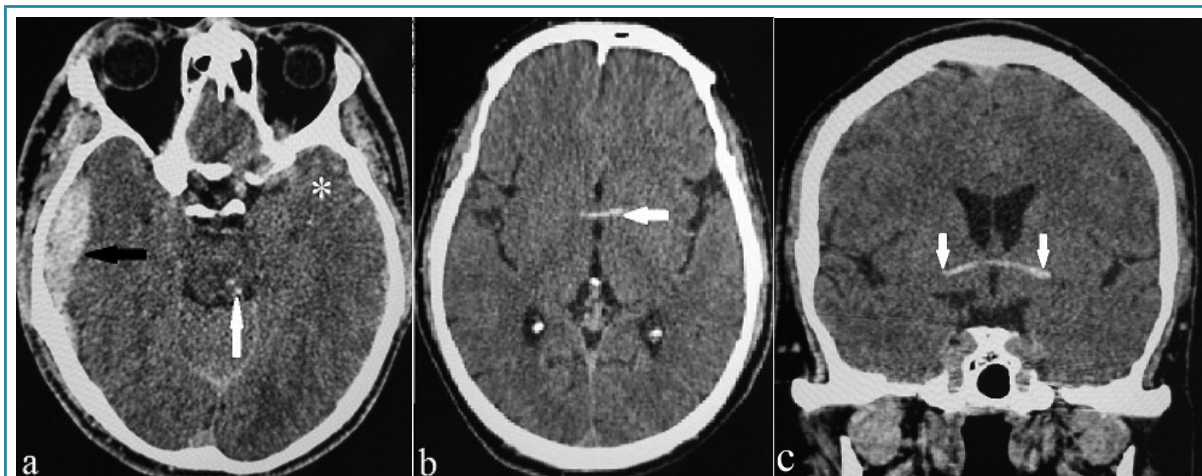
Diffuse axonal injury. (a) Non-contrast axial CT image of a 22 years old male after RTA demonstrates two petechial hemorrhages (white arrow) in posterolateral aspect of mid-brain with right temporal region EDH (black arrow), left temporal lobe contusion (*) and right temporal bone fracture (not shown). (b, c) Axial and coronal reformatted images of 33-year-old male after fall injury demonstrate hemorrhage (arrow) along anterior commissure fibers. No fracture was identified
